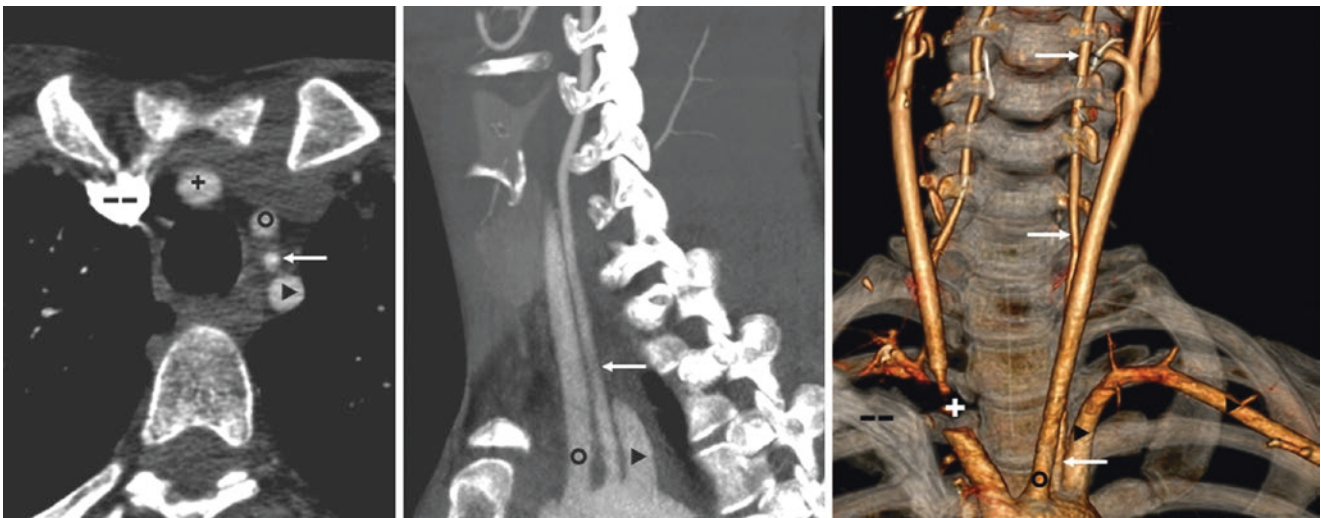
In a 31-year-old, axial CTA source images (left) depict an “arch origin” of the LVA (arrows), situated between the LCCA and LSCLA on an LAO 9-mm sagittal MPR (middle), as well as on a 3D VR CTA in an AP view (right). Note that the IA (plus sign) is focally obscured owing to streak artifact from contrast within the superior vena
